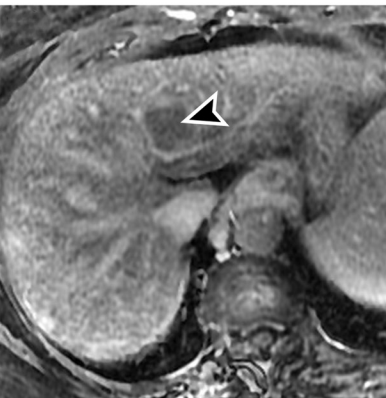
Capsule appearance in a 63-year-old woman with a lesion categorized as LR-5 (definitely HCC) on the basis of major imaging features. Axial dynamic nonenhanced (a), late arterial phase (b), portal venous phase (c), and delayed phase (d) MR images show a 27-mm nodule with APHE (arrow in b), washout (arrowhead in c), and a capsule (arrow in d). This is an example of an enhancing capsule, as it is visible as an enhancing rim; a nonenhancing capsule would be visible as a nonenhancing rim.
